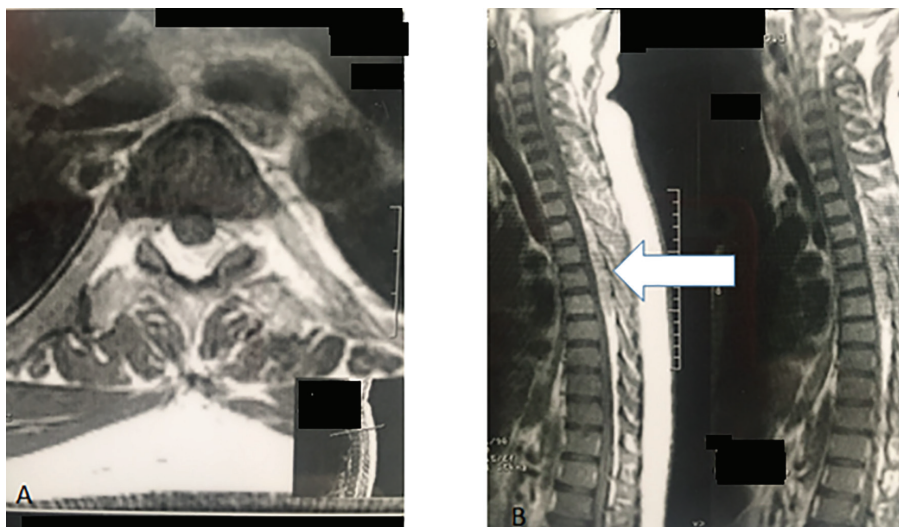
Axial and sagittal T1-weighted MR imaging after treatment with hydroxyurea. Significant improvement evidenced by absence of intraspinal masses of extramedullary hematopoiesis.
